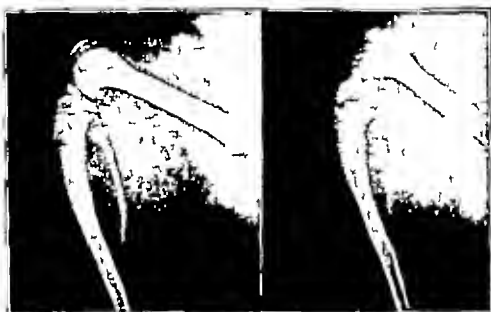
Roentgenograms of lower extremity. Left Control no rickets. Right Steenbock diet advanced active rickets.
